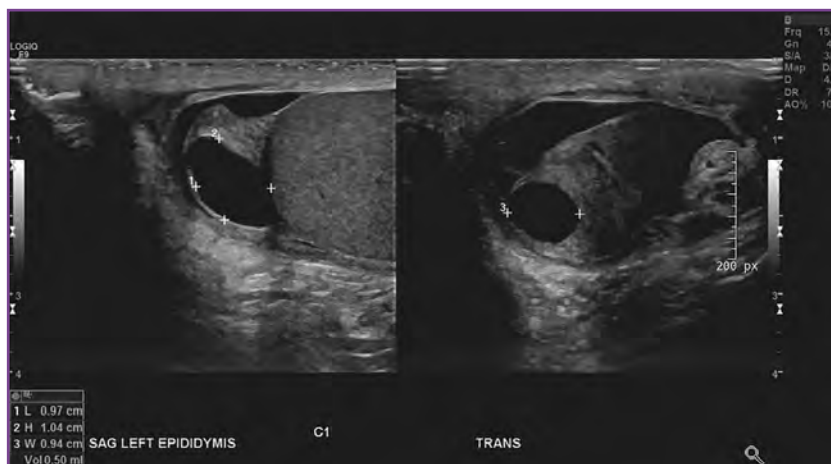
Ultrasonographic images of spermatocele in a 15-year-old boy with a scrotal mass palpated at his annual visit to his primary care physician.
